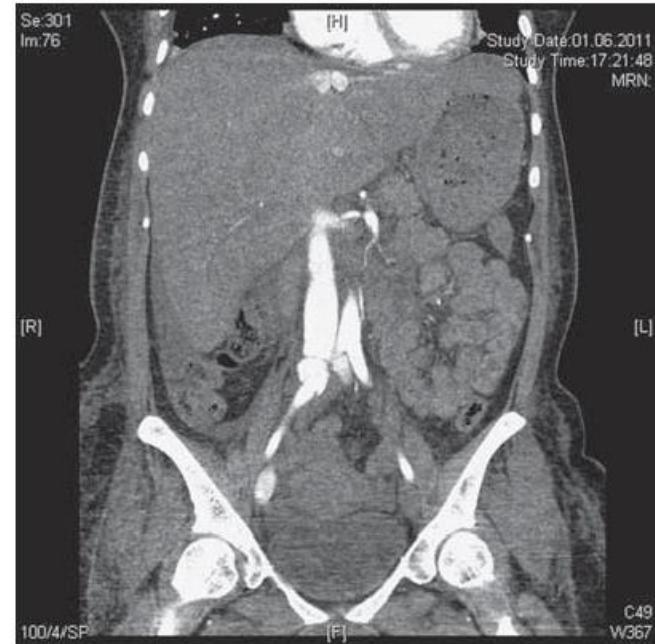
The computed tomography (CT) shows that the liver is greatly enlarged; the spleen moderately so. Fluid can be seen within the abdomen. Contrast agent can be seen in the aorta to the bifurcation. Contrast immediately fills the inferior vena cava, leaving little for the renal parenchyma and lower extremities.
